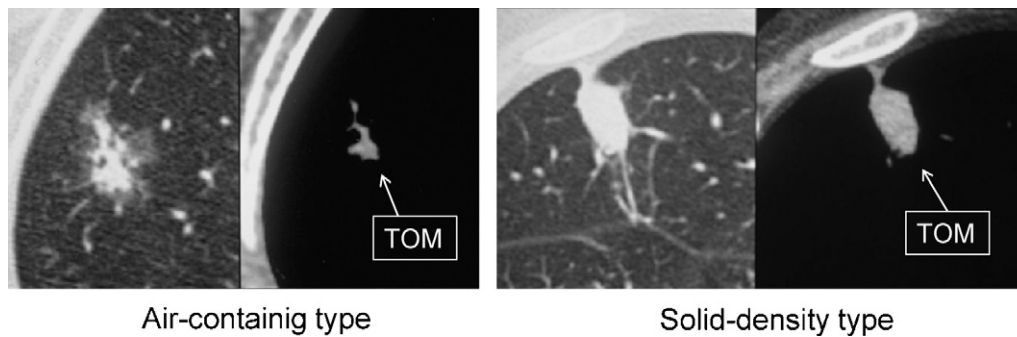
TS-CT images of 'air-containing type' and 'solid-density type'. Air-containing type: the areas of tumor opacity on mediastinal window images (TOM) are half or less than half the size of those noted on lung window images. Solid-density type: the areas of tumor opacity on mediastinal window images (TOM) are greater than half the size of those noted on lung window images.
